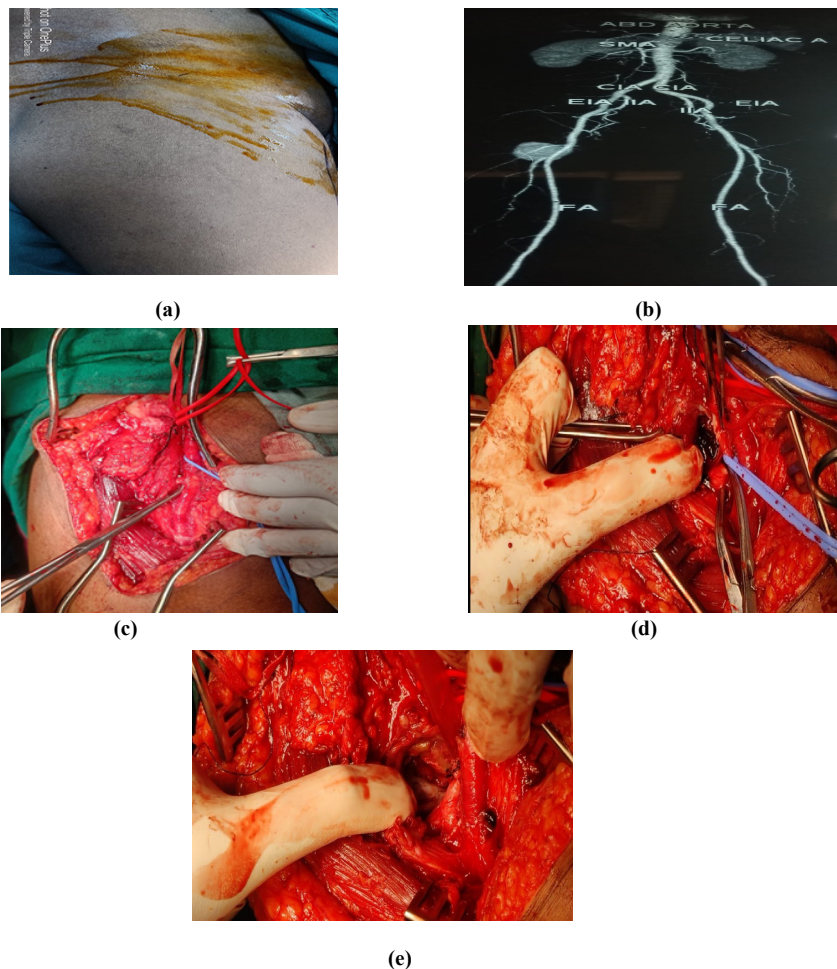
(a) 56/Male, known HTN, right upper thigh swelling and pain 9 days following trivial trauma. (b) CT angio: 6x 4.2x 4.6cm right profunda femoral artery pseudoaneurysm. (c) CFA, SFA and PFA controls taken. (d) Sac evacuated, and PFA ligated. (e) PFA is ligated proximally and distally to the origin of pseudoaneurysm.
